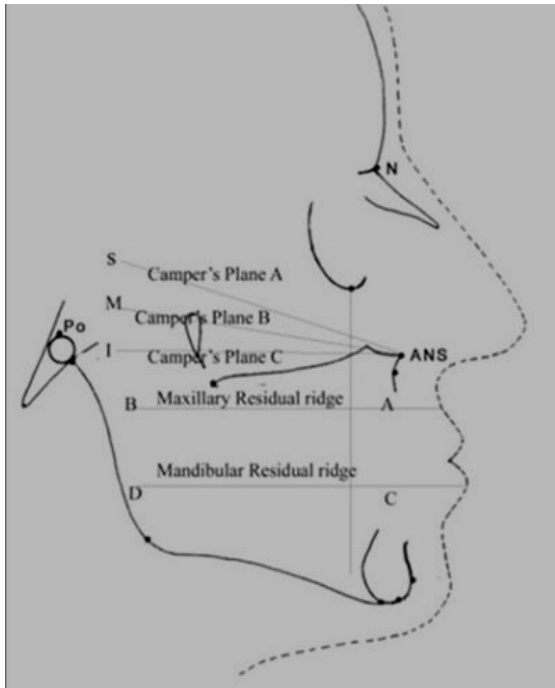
Lateral cephalometric radiographs Depicting the landmarks
